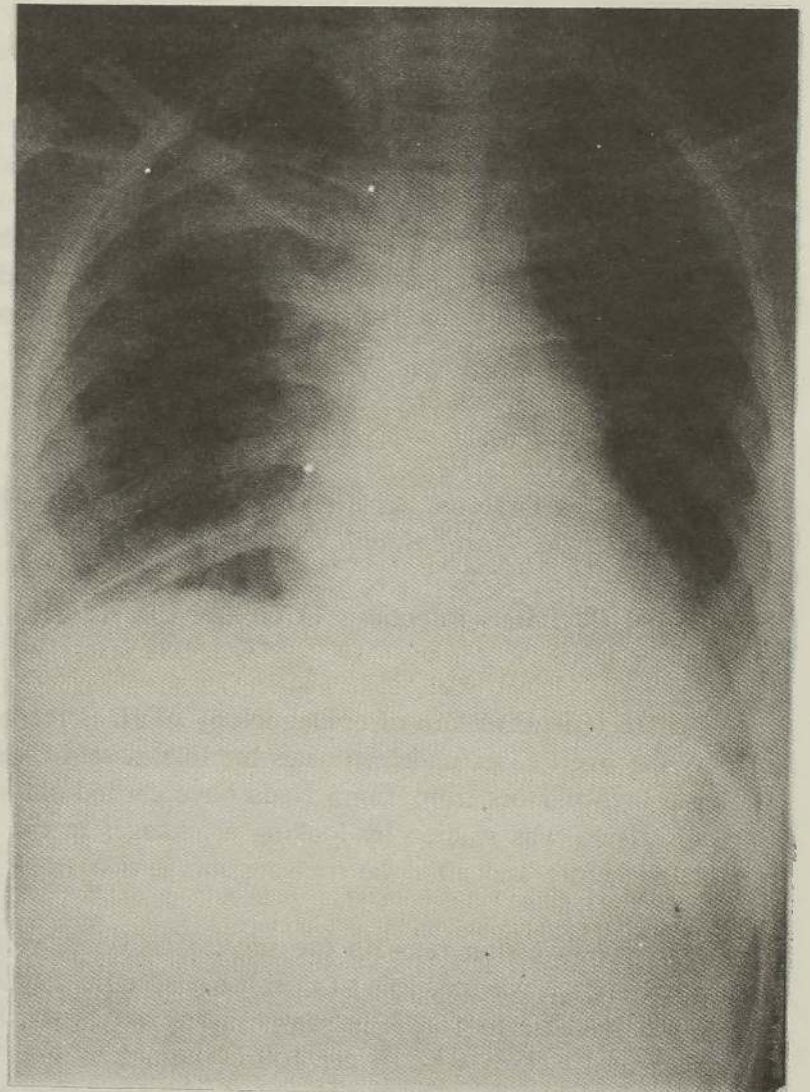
Chest xray after treatment.
